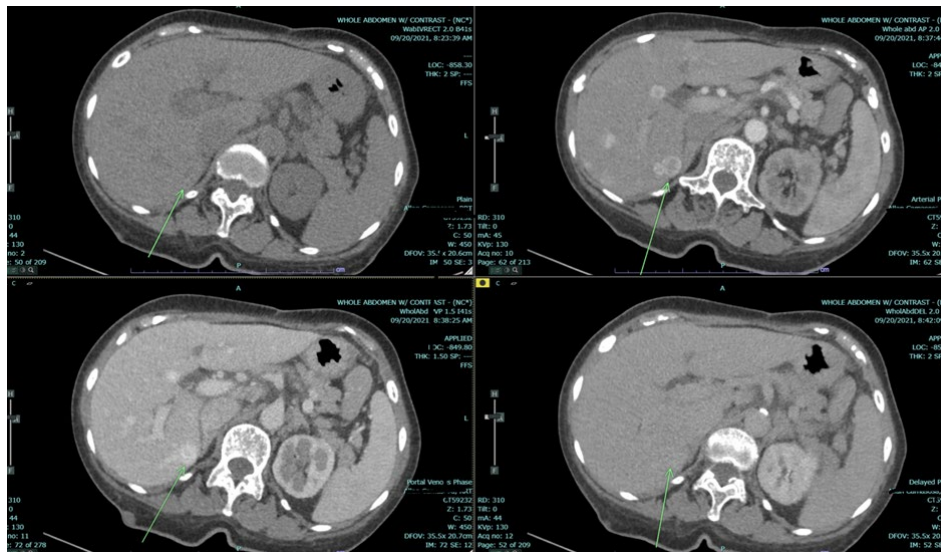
Multiple hepatic nodules with flash-filling hemangiomas noted on whole abdomen CT scan with IV contrast.
